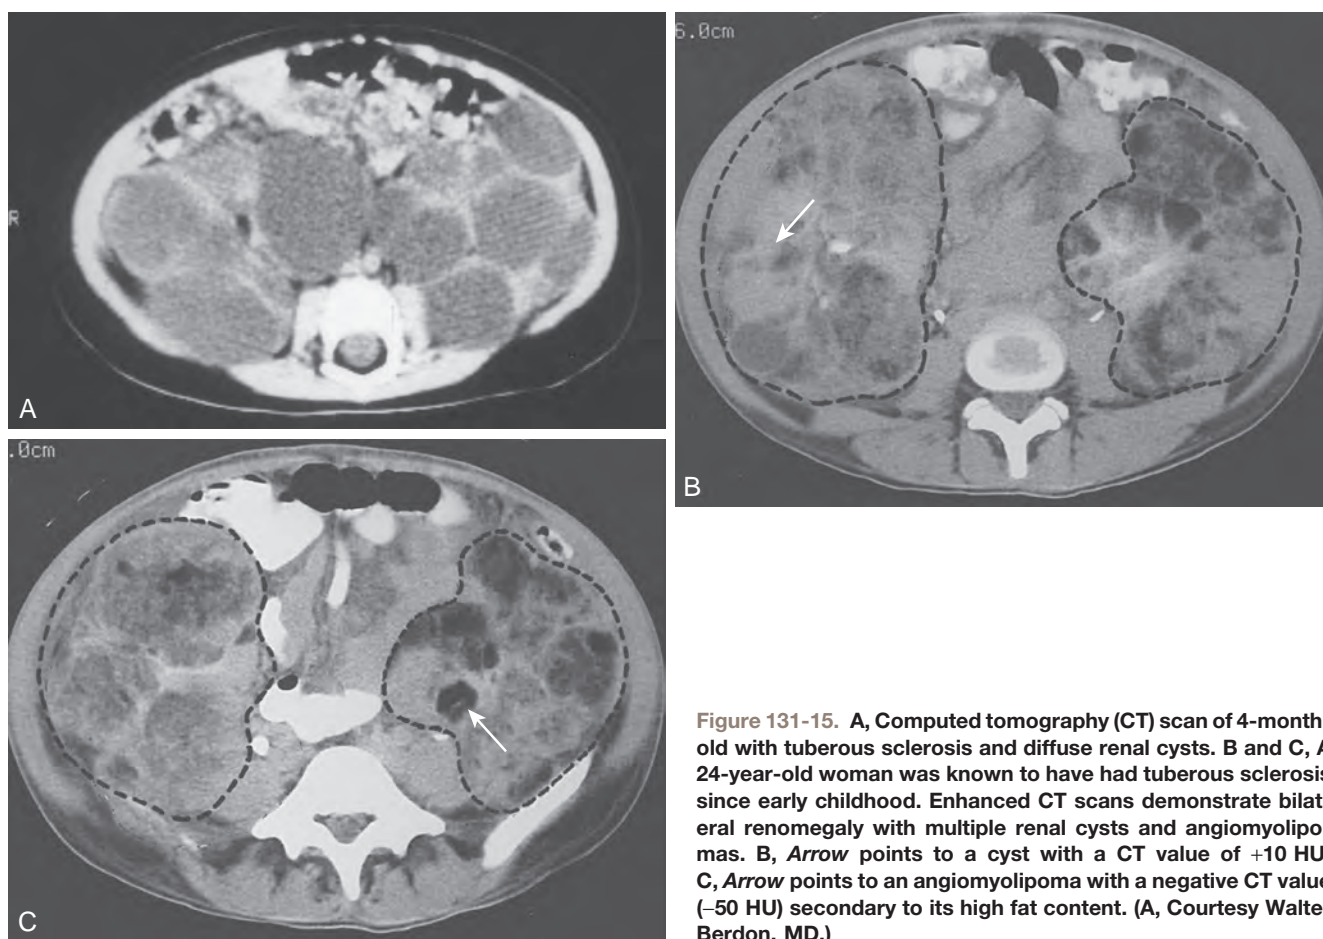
A, Computed tomography (CT) scan of 4-month-old with tuberous sclerosis and diffuse renal cysts. B and C, A 24-year-old woman was known to have had tuberous sclerosis since early childhood. Enhanced CT scans demonstrate bilateral renomegaly with multiple renal cysts and angiomyolipomas. B, Arrow points to a cyst with a CT value of +10 HU. C, Arrow points to an angiomyolipoma with a negative CT value (-50 HU) secondary to its high fat content. (A, Courtesy Walter Berdon, MD.)
